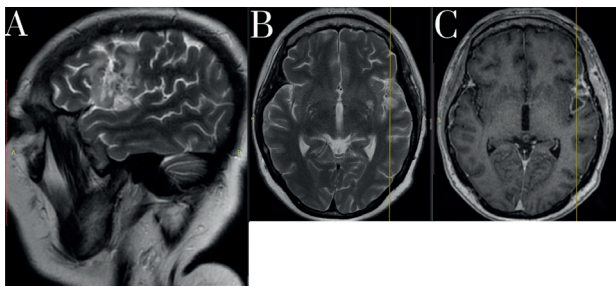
3 months follow-up MRI examination with contrast. A: Sagittal T2 Propeller view with an apparent decrease of enhancement. B: Axial T2 Propeller. C: Axial T1 fat-suppressed fast spoiled gradient echo with contrast enhancement on the periphery demonstrates slight residual tissue, not expanded over time.
